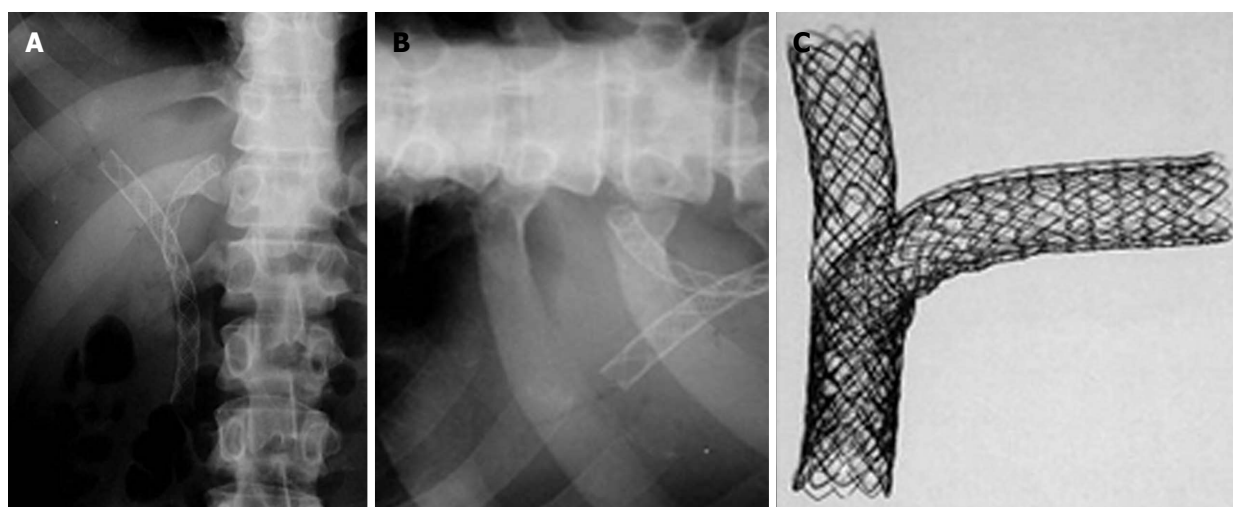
Percutaneous double stenting. A: X-ray showing the Y configuration of the stent (Boston Scientific MA, United States); B: Transverse limb of a T stent (Taewoong Medial, South Korea) showing the open mesh in the center; C: Assembly of a T stent showing the vertical stent passing through the open mesh of the transverse stent.
